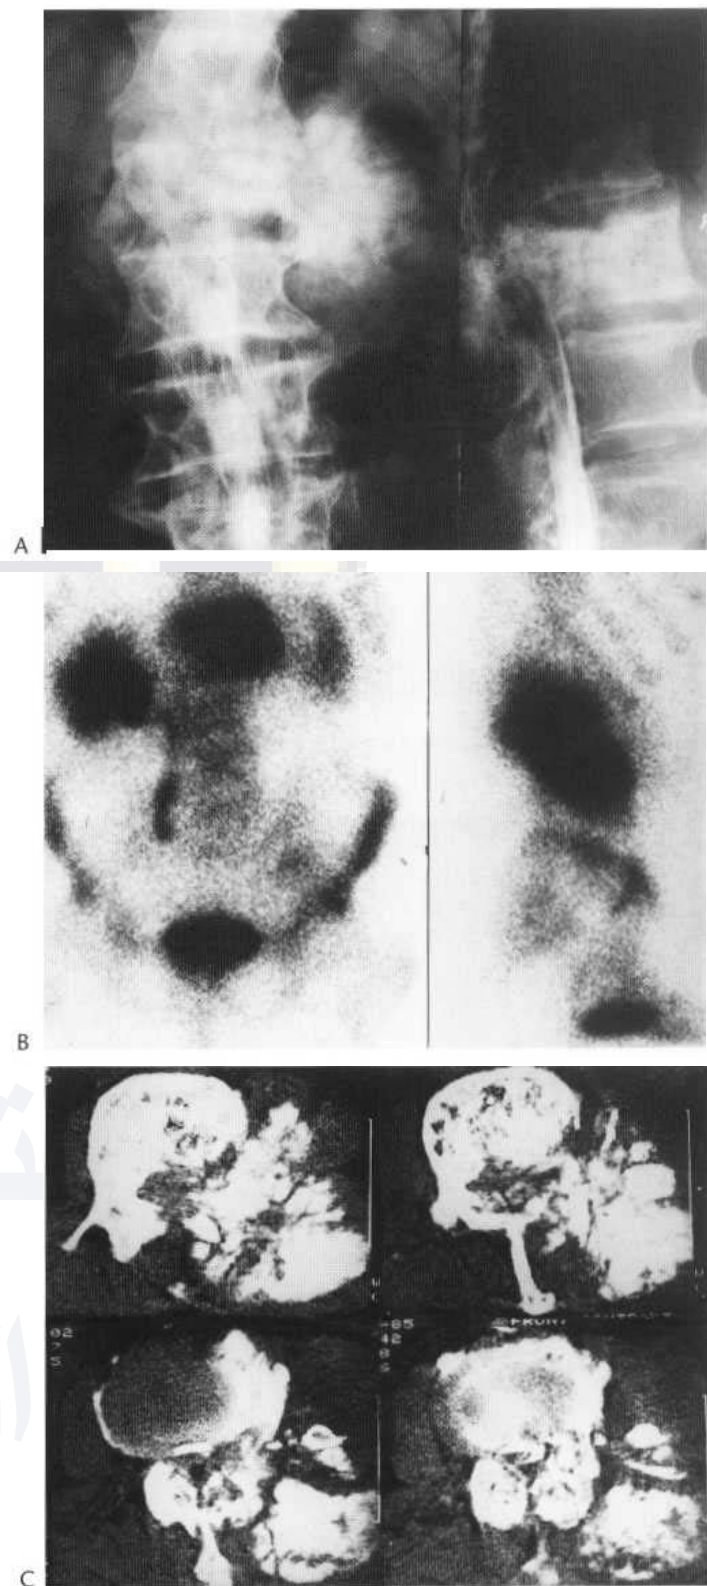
Osteogenic sarcoma in Paget's disease. (A) The radiograph shows an ossifying mass in the soft tissues adjacent to the abnormal vertebral body at L2. This in turn shows expansion with sclerosis. There is hold-up of contrast medium at that level. The pathology extends into the neural arch. (B) The radioisotope bone scan confirms the presence of change at this level and also shows ureteric obstruction, presumably by pathologically enlarged lymph nodes in the pelvis. (C) The CT scan confirms the presence of sclerotic Paget's disease within the vertebral body but also demonstrates the ossifying sarcomatous mass in the soft tissues. The spinal canal is encroached upon. (Courtesy of Dr K. Walmsley.)
